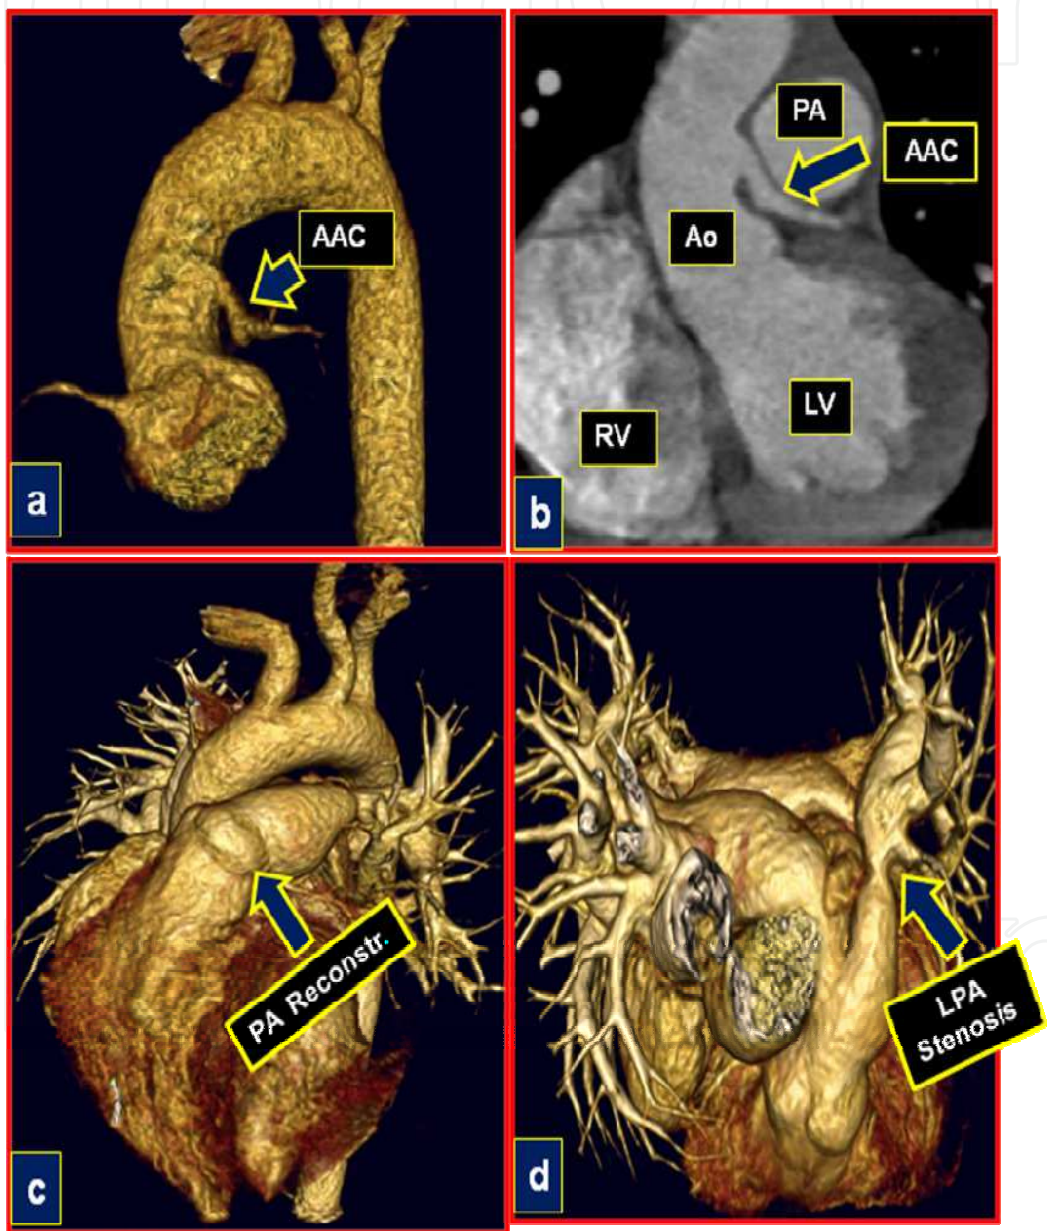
Late follow-up of the 8th year. Postoperative image of CT angiography- a- Implantation of *Autologous* arterial conduit (ACC) in the ascending aorta above the aortic sinus. b- Autogenous arterial conduit patency, with uniform diameter. c- Reconstruction of the pulmonary artery . -d- Image of stenosis located in the distal left pulmonary artery. (LPA); RV: right ventricle; LV: left ventricle; PA: pulmonary artery; Ao; aorta
